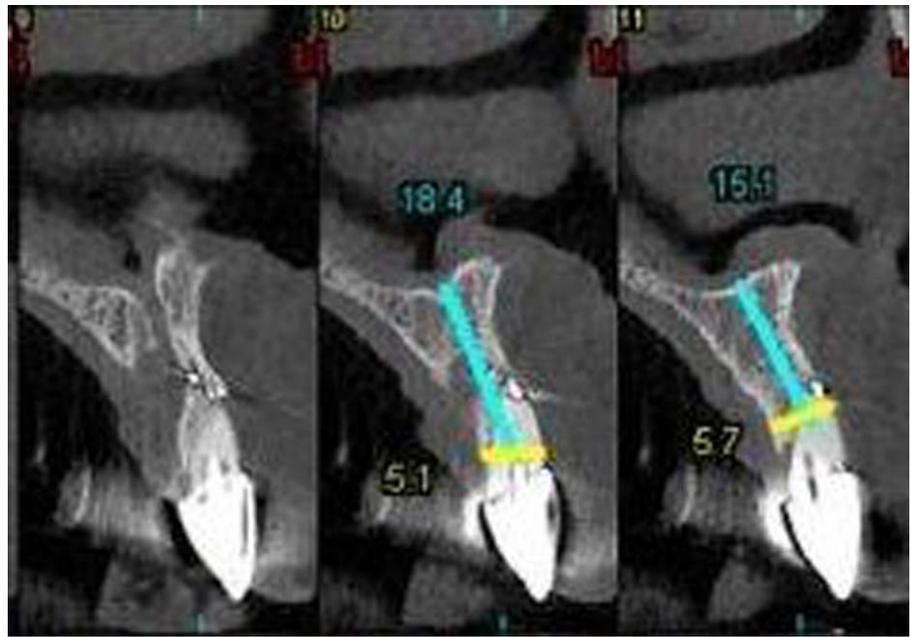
CT scan demonstrating missing coronal buccal bone and periapical radiolucency of hopeless left central incisor.
